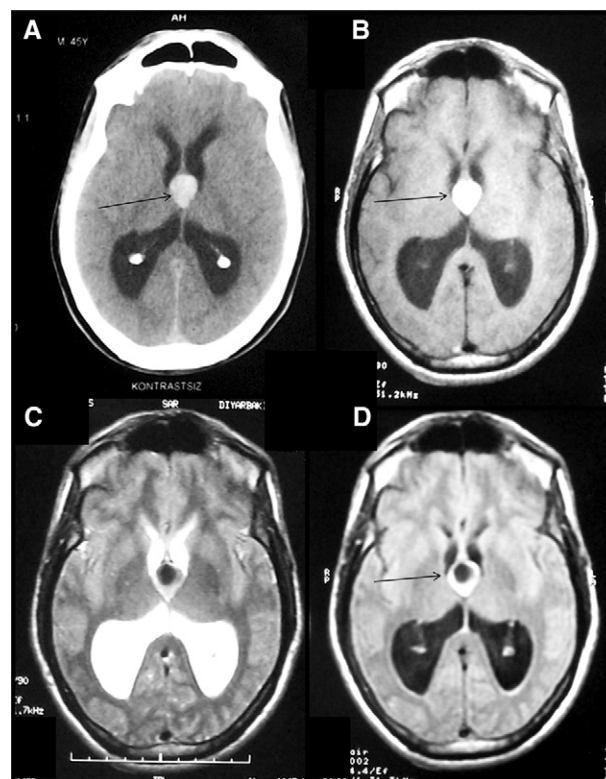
A 46-year-old male patient. (A) There was hydrocephalus and a 2-cm-diameter lesion hyperdense in appearance on axial computed tomographic evaluation, which was compatible with a colloid cyst (arrow). Although the lesion was hyperintense in axial T1-weighted images (B) (arrow), its centre was hypointense and the periphery was hyperintense on T2-weighted (C) and fluid-attenuated inversion recovery (D) images (arrow).
